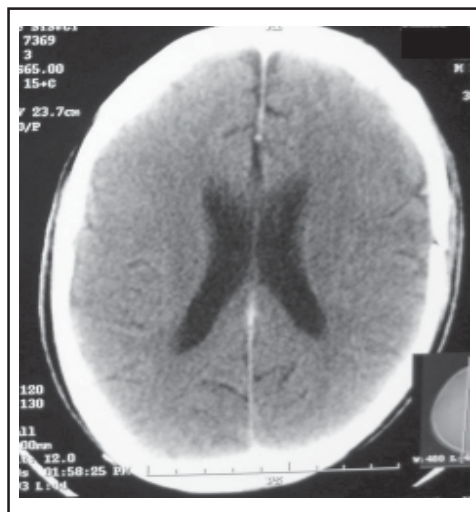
Follow up contrast CT scan showing complete resolution of subdural collection.
